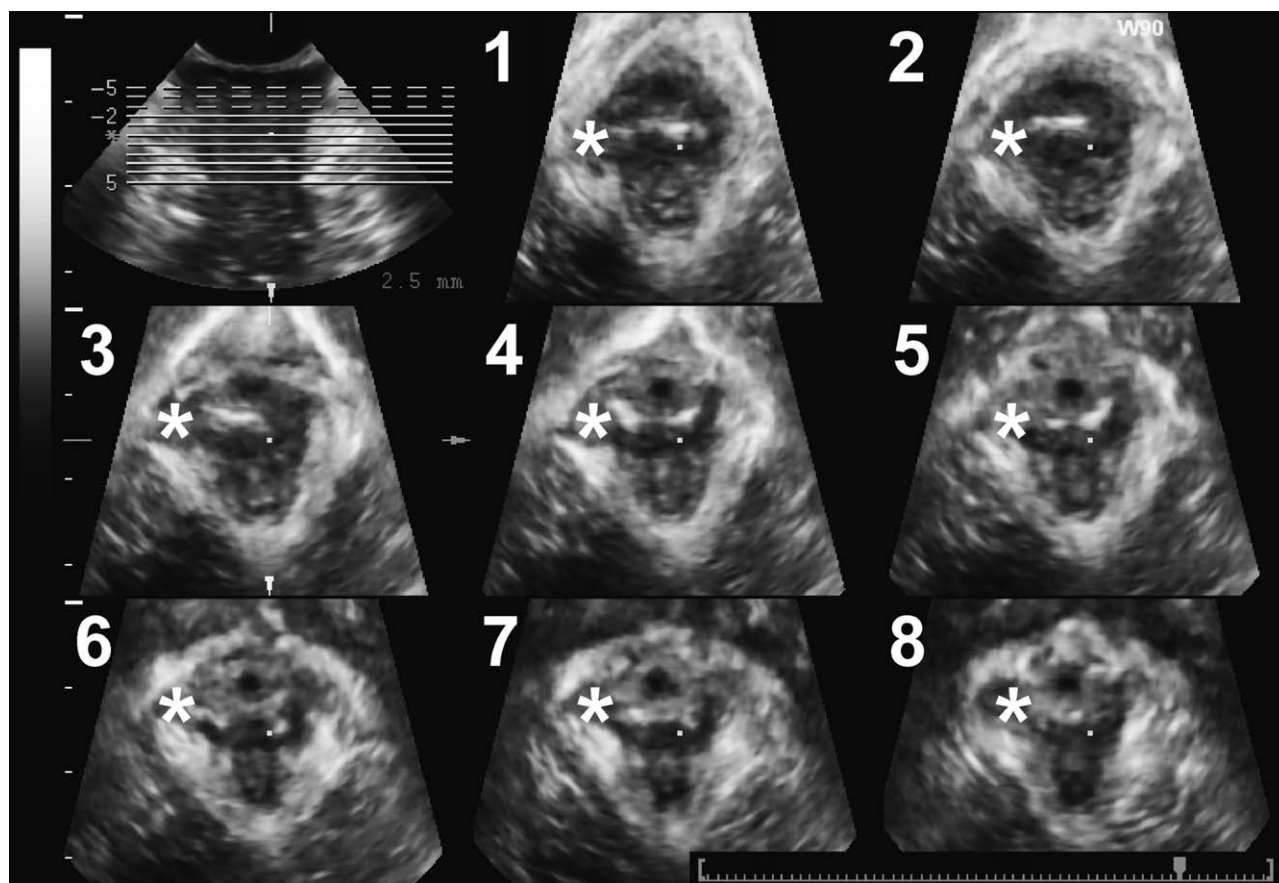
Tomographic ultrasound imaging (TUI) showing a right-sided levator avulsion. The defect is marked with '\*'.
